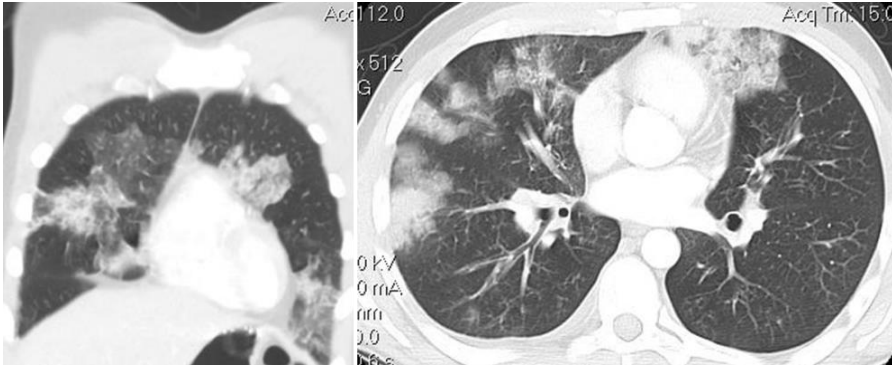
Patchy lung alveolar interstitial infiltrates in a patient with eosinophilic granulomatosis with polyangiitis (frontal and axial CT images).
